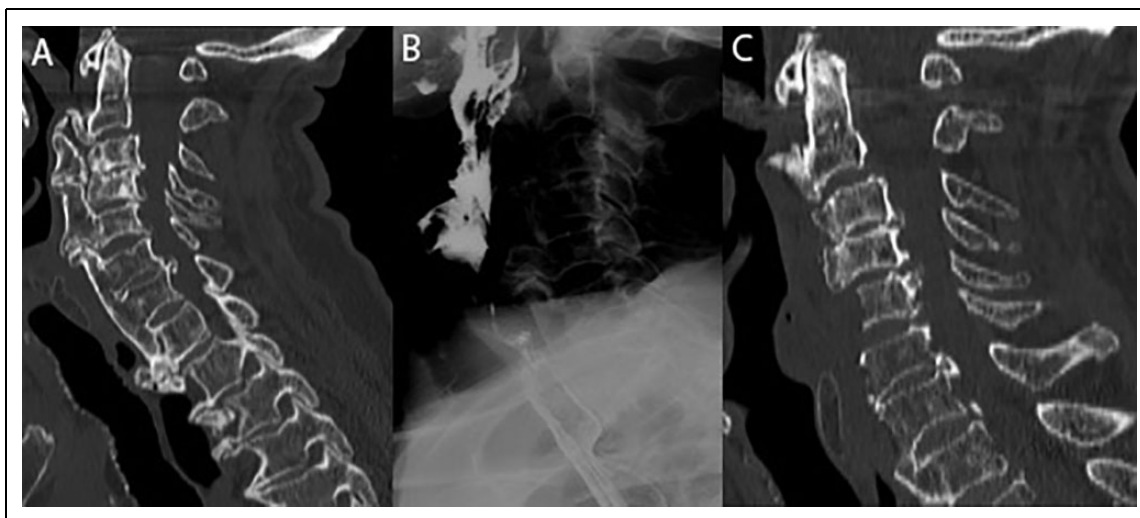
(A) Preoperative cervical spine CT-scan of an ultra-elderly patient suffering from an extended DISH with the most prominent bony spurs in T1-T2 and C5-C6; (B) preoperative videofluoroscopic barium swallow study showing a severe C5-C6 obstruction most likely responsible of symptoms (C) 12-month CT-scan control after C3-C7 bone decompression.
